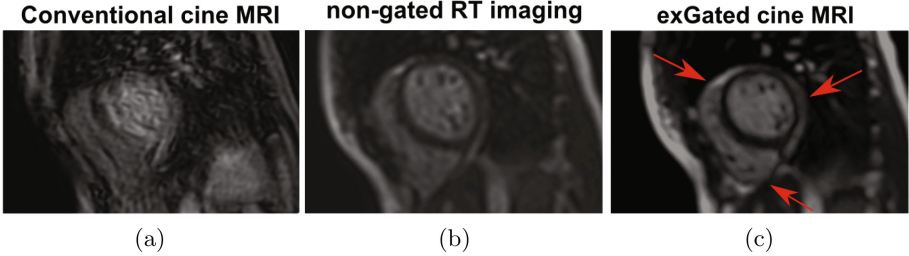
Cardiac reconstructed MRI images: (a) conventional cine MRI, (b) non-gated RT MRI [10], (c) proposed approach - exGated cine MRI. Arrows denote better delineation of pericardium fat and RV wall of the proposed method.
